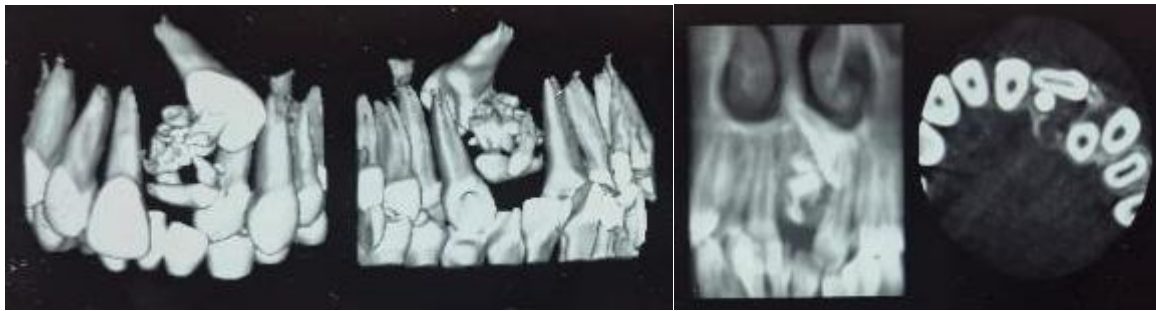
CBCT sections showing compound odontoma in relation to impacted 21
